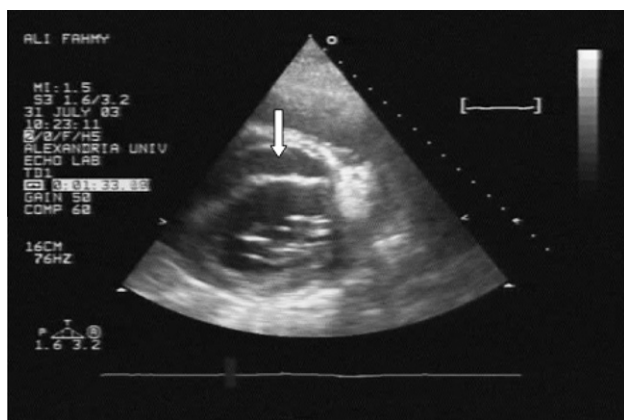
Parasternal short-axis view of left ventricle shows ruptured sinus of Valsalva aneurysm dissecting into interventricular septum (arrow).
